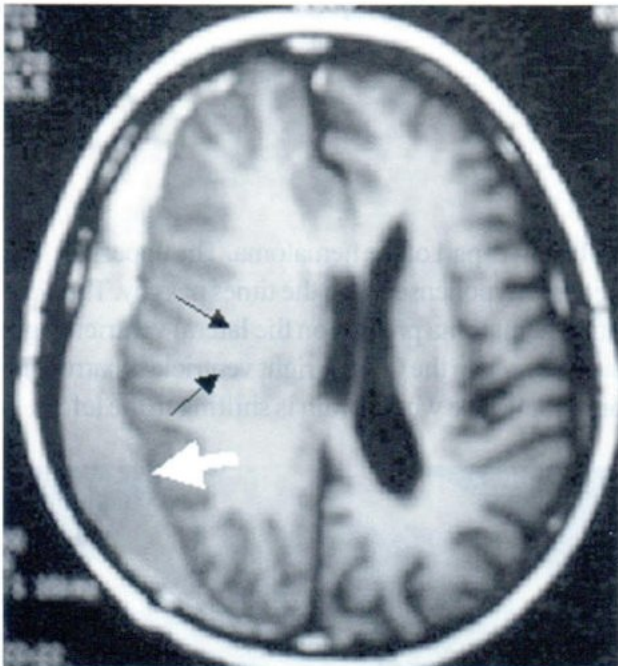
A MRI, T_1W_1 Black arrows indicating intracerebral hematoma filling up the left ventricle.
